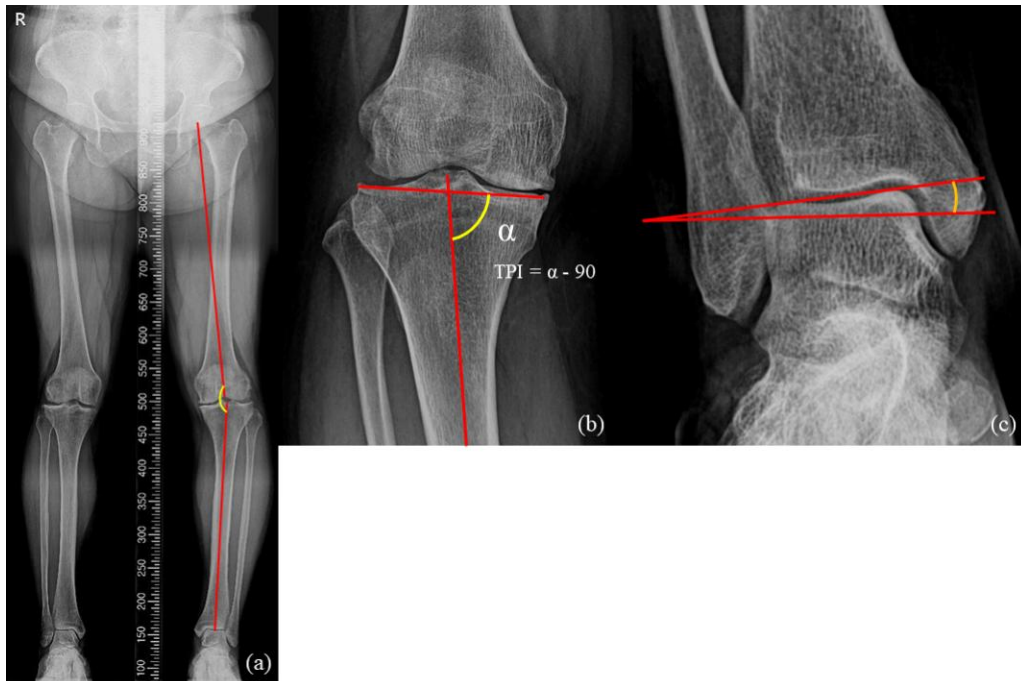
Radiologic parameters in standing radiograph. (a) Hip-knee-ankle angle, (b) TPI, (c) G-AJLO. G-AJLO: ankle joint line orientation; TPI: tibia plateau inclination.
